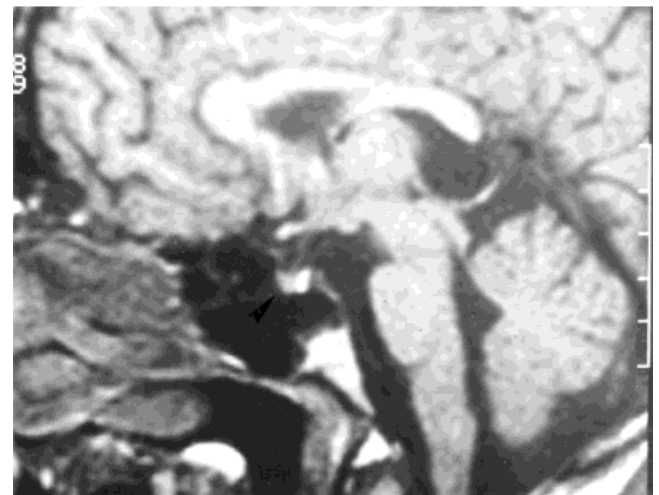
MRI of brain of patient 1, showing a hypoplastic pituitary gland.
